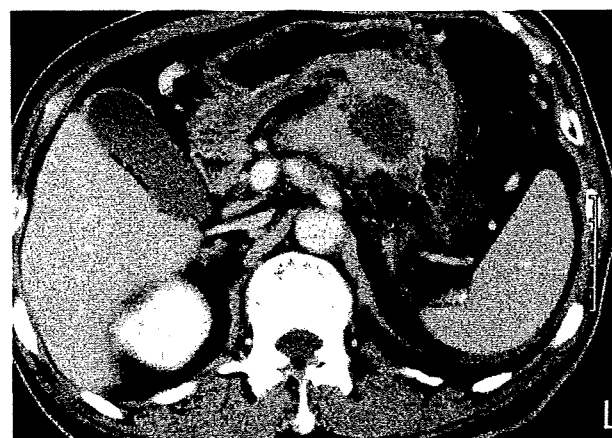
Abdominal CT 19 days later showed a pseudocyst in the pancreatic body and tail.
